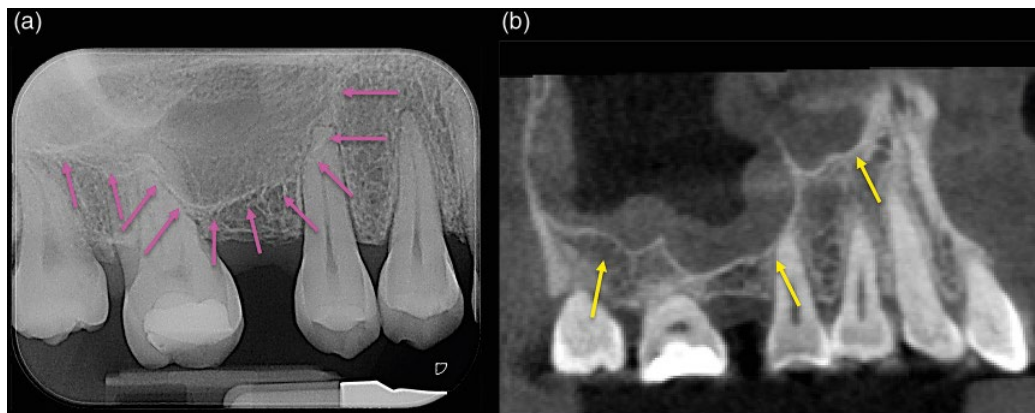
Maxillary sinus. (a) Periapical radiograph of the maxillary right posterior teeth demonstrating the inferior border of the right maxillary sinus represented by a thin, poorly defined radiopaque line (pink arrows). (b) Sagittal CBCT view accurately demonstrating the true dimensions of the maxillary air sinus and its multiple lobes (yellow arrows).
